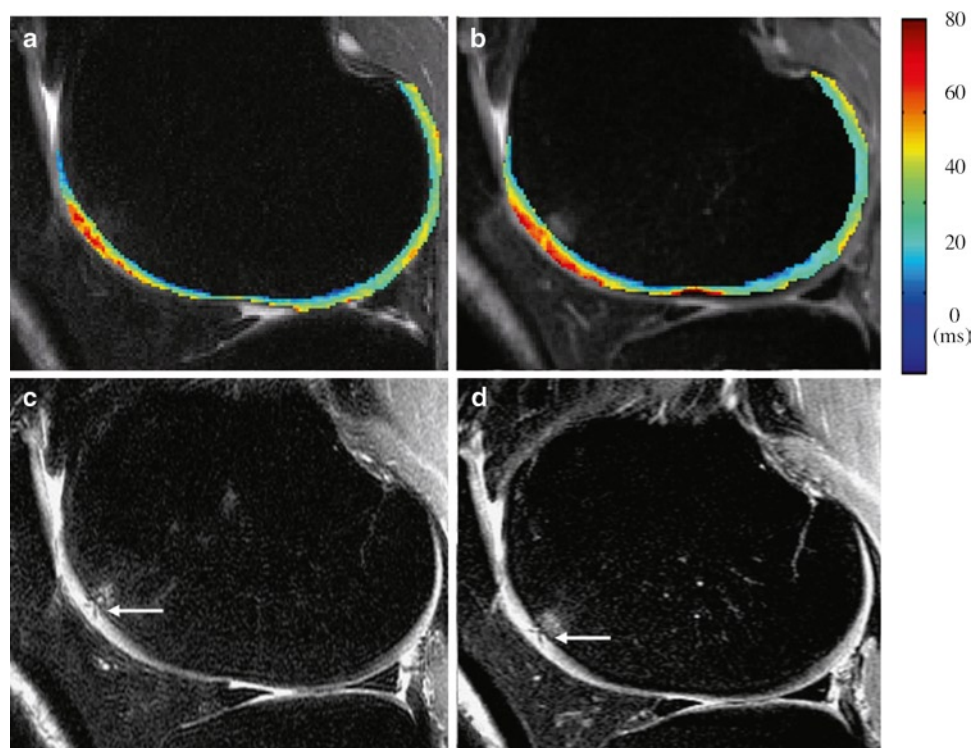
$T_{1\rho}$ color-coded maps obtained in a 57-year-old man with mild OA at baseline (a) and 1-year follow-up (b). Sagittal fat-suppressed T2-weighted fast spin-echo image obtained in the same patient at baseline (c) and 1-year follow-up (d). $T_{1\rho}$ values of lateral femoral condyle were significantly higher in cartilage overlying (OC) the BMEL than surrounding cartilage (SC) at both baseline and 1-year follow-up. From baseline to 1-year follow-up, the $T_{1\rho}$ values increased
